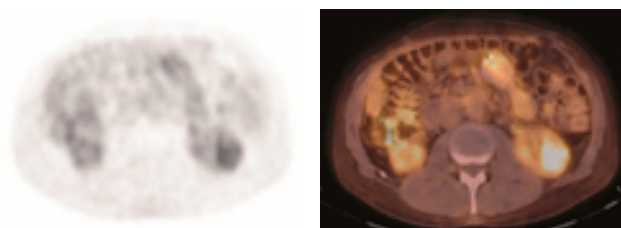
A 48 year old man with papillary RCC. Axial ^{18}F -FDG-PET and fused PET/CT images reveal 3.8cm mildly ^{18}F -FDG avid mass in interpolar left kidney with SUVmax 3.7, SUVmean 2.9, partial volume corrected SUVmean 7.9, LBRliver 1.8, and LBRkidney 2.1.
